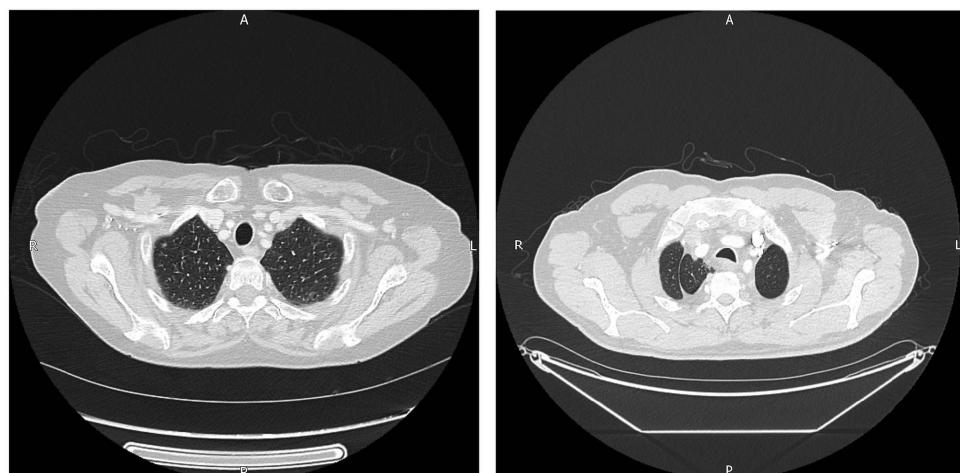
Left CT scan showing normal trachea. Right CT shows abnormal trachea of the patient discussed. Permission gained from trust with consent.
